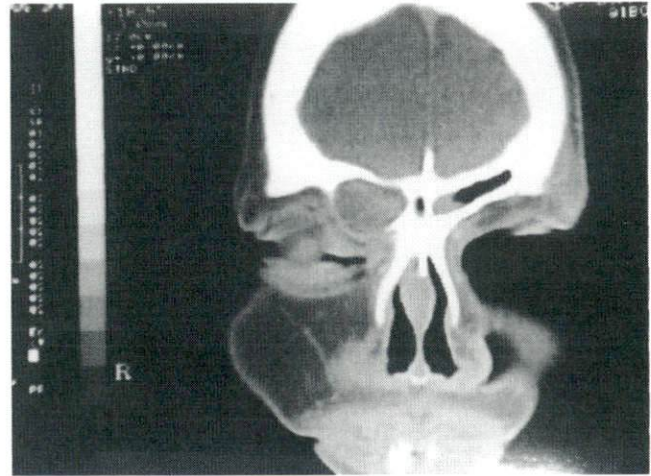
Computed tomography scan showing the plasmacytoma in the frontoethmoid and in the frontal area over the eye.
